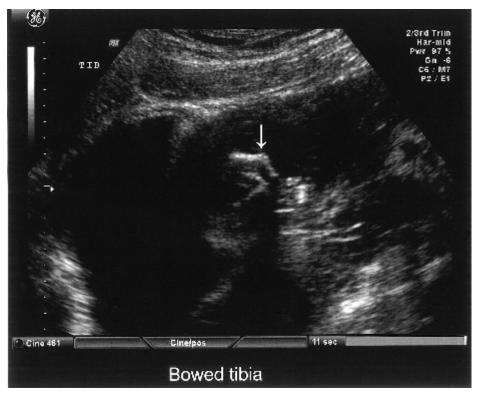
Sonogram of a 16-week, 6-day-old fetus with bilateral bowed tibias.
